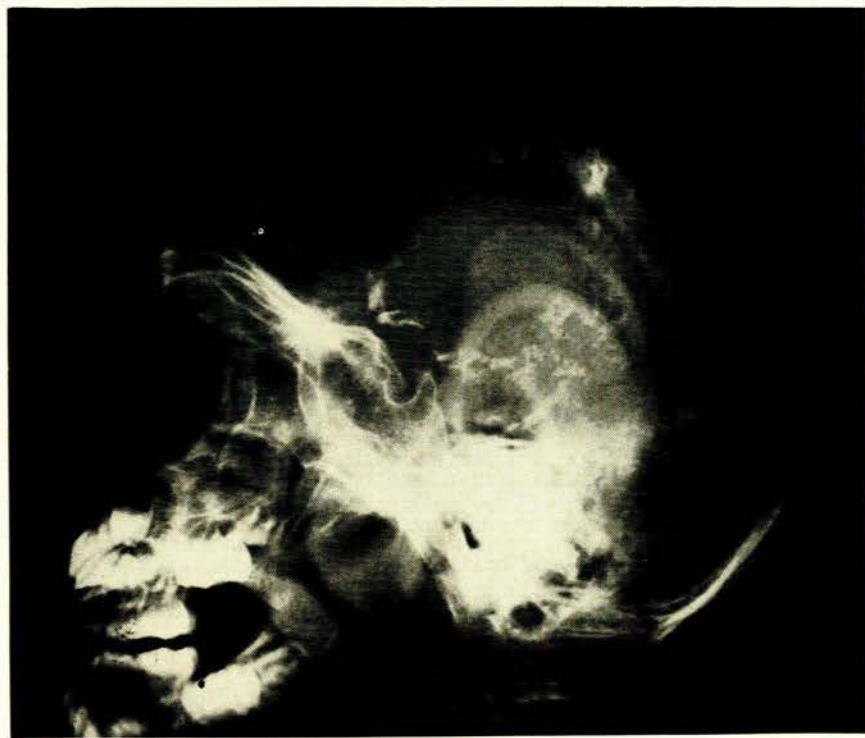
Lateral X-ray of the skull showing microcephaly and paraventricular calcification in a case of congenital cytomegalovirus infection.
